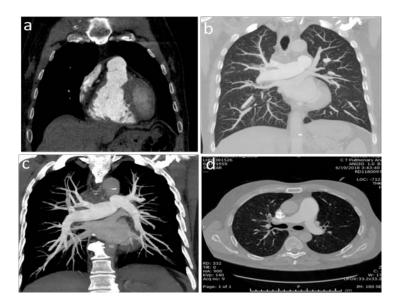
HRCT thorax (a,b) and Pulmonary CT angiogram (c,d) revealed no pulmonary thromboembolism or other pulmonary parenchymal lesions.
